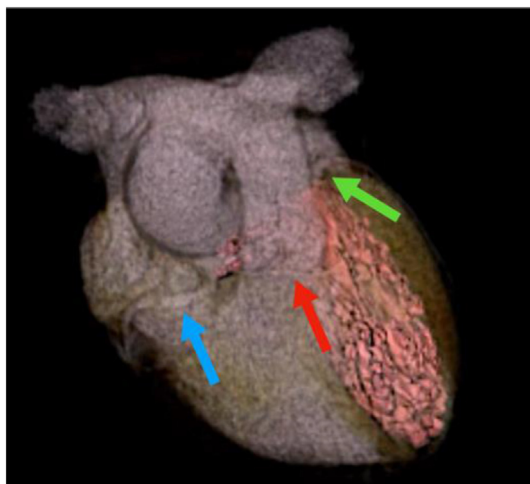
(far right): CT heart 3-dimensional coronary with calcium revealed the LAD originating from the right sinus of Valsalva, 1.5 mm inferomedial to the RCA, passing anterior to the pulmonary artery (red arrow) to supply the left ventricle. Additionally, the LCX was absent, and a large dominant RCA (blue arrow) and a posterolateral branch supplied LCX territory along the lateral cardiac border (green arrow).
